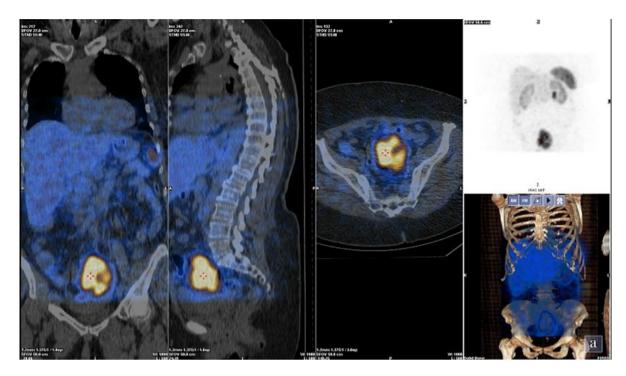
SPECT CT - data on pathologically increased expression of somatostatin receptors in a tumor formation
